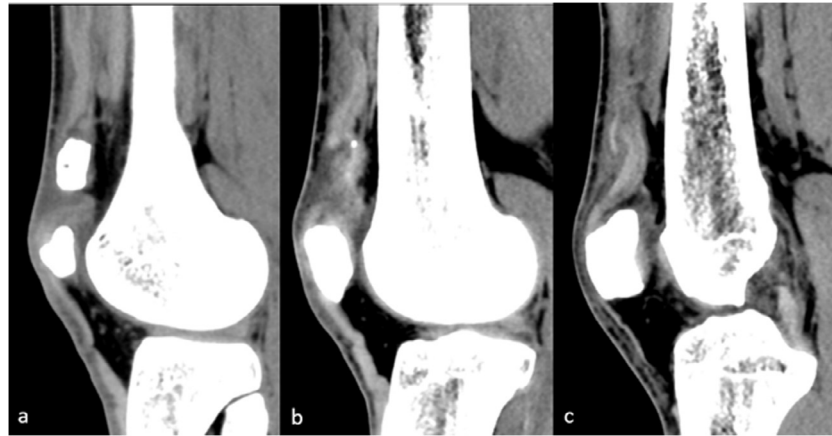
Three sagittal CT slices of the knee demonstrating separated bipartite fragment with retraction of the ligamentous attachment (Fig 2A), smaller avulsed patellar fragment with retracted ligamentous attachment and adjacent fluid (Fig 2B), and subtle retraction and heterogeneity of the quadriceps tendon attached to the patella suggesting laxity and partial tear (Fig 2C).
